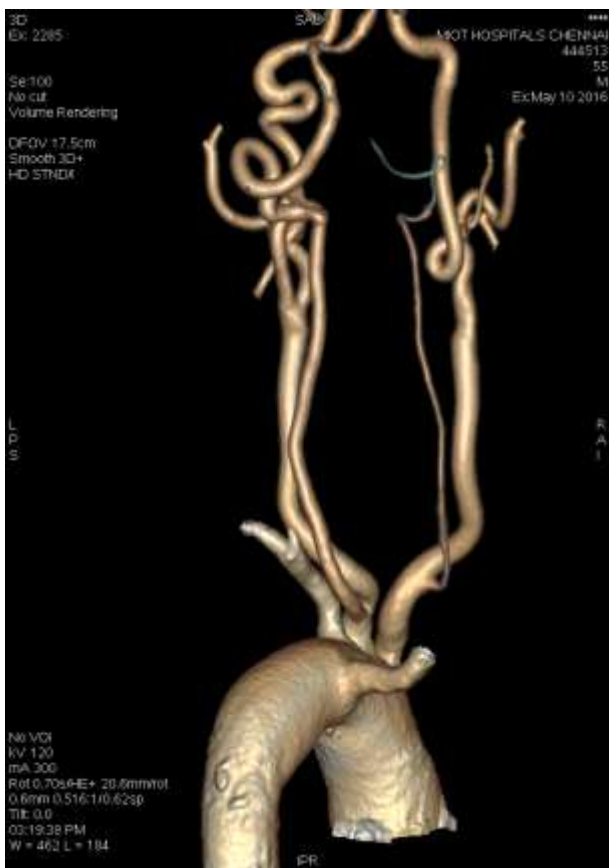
3D Reconstruction of CT angiogram showing the origin of right subclavian artery from the posterior aspect of arch of aorta distal to the origin of left subclavian and the vertebral arteries arising from the common carotid arteries
